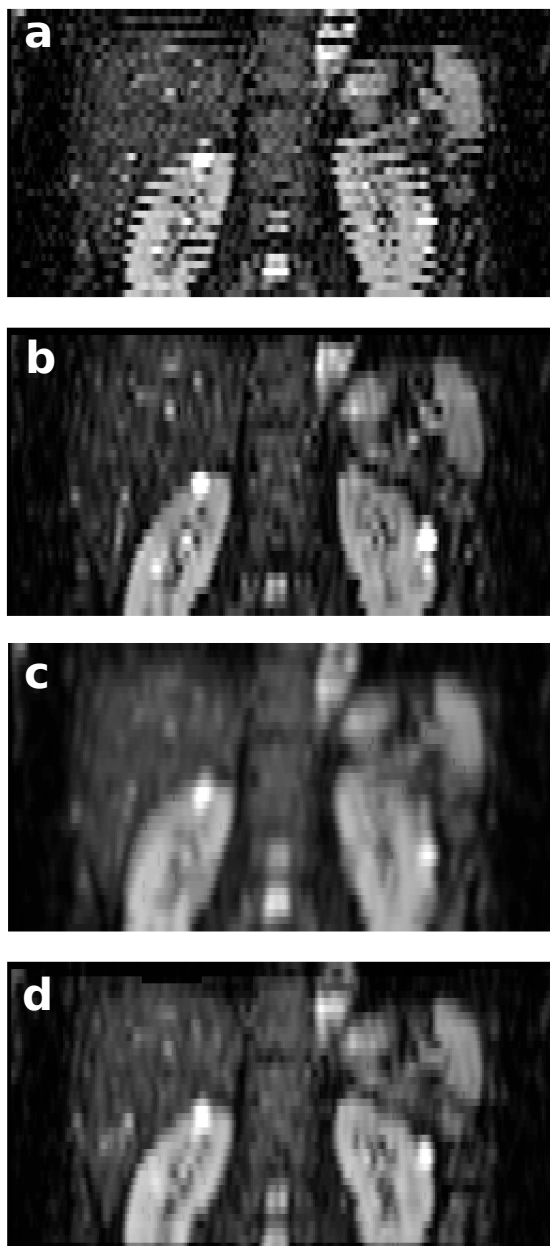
Coronal $b = 0 \text{ s/mm}^2$ DW-MR images. 'No processing' scenario (a), 'interpolation' scenario (b), 'Gaussian blurring' scenario (c), and 'image registration' scenario (d).
